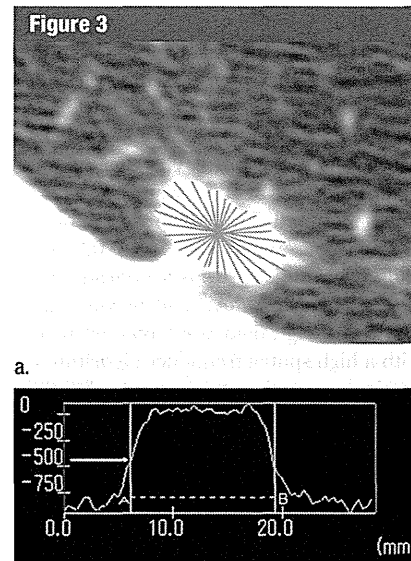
Threshold CT value between a tumor and surrounding normal lung parenchyma in a 60-year-old woman. (a) CT density profile curves are drawn through center of nodule at 10° intervals. (b) A representative profile curve shows CT value at FWHM is -545 HU (arrow). The mean CT value derived from all 36 profile curves on each axial section is used as the threshold CT value.
